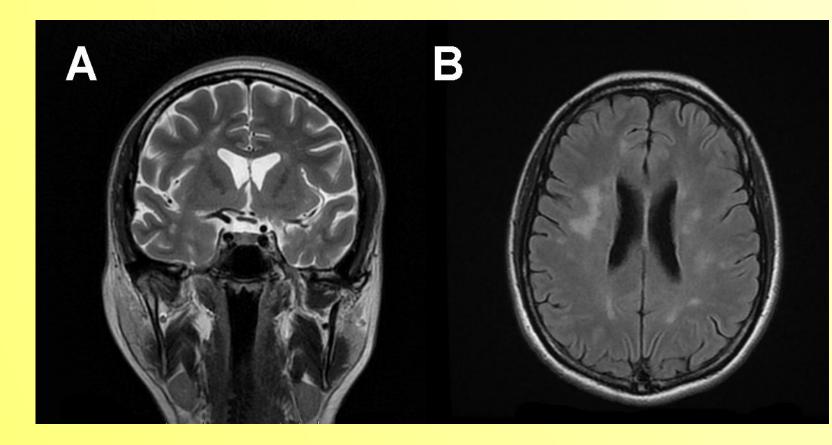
After two months of treatment the ADEM lesions appear reduced in T2-weighted (A) and FLAIR (B) sequences
